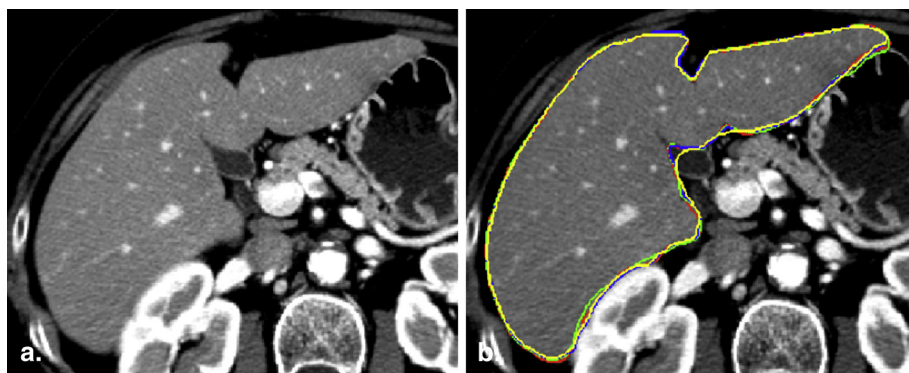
A 67-year-old woman with colorectal metastases. Original (a) and annotated (b). Axial computed tomography slice demonstrating concordance between four readers using manual and semiautomated liver segmentation methods. Reader-1 manual = red tracing, reader-2 manual = green tracing, reader-3 semiautomated = blue tracing, reader-4 semiautomated = yellow tracing. (Color version of figure is available online.)
